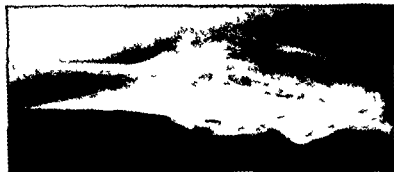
Roentgen ray of the femur showing spontaneous fracture and vanthomatous pseudo cysts (case XL)
